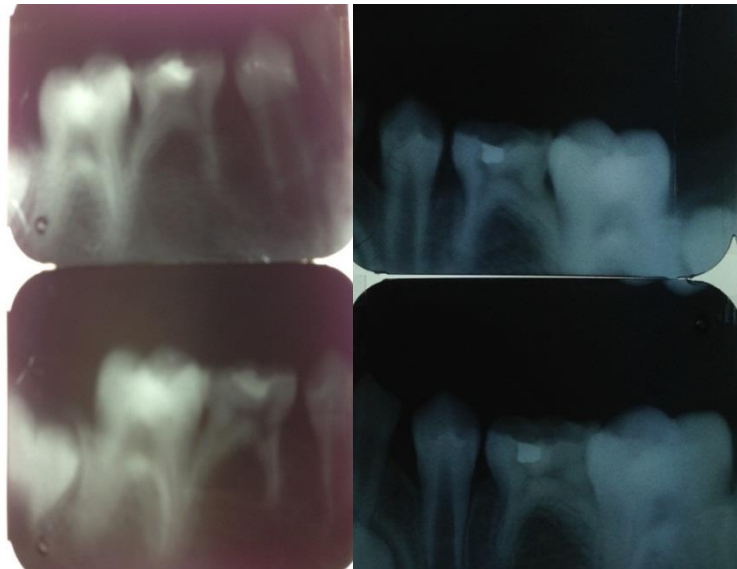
Radiographical evaluation immediately and after six-months follow-up examination scores of the restorations.
